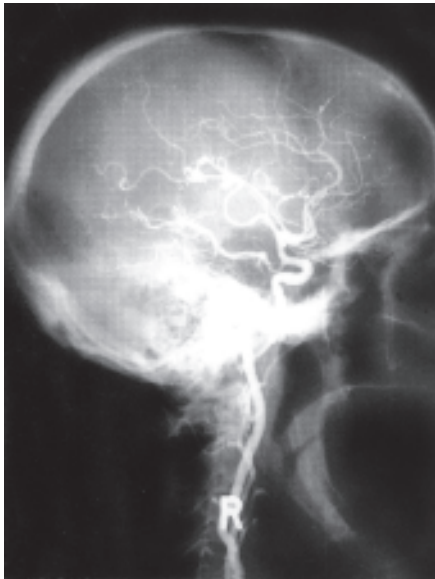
Radiographer contrast media in the branches of the right internal radiograph following a barium meal
